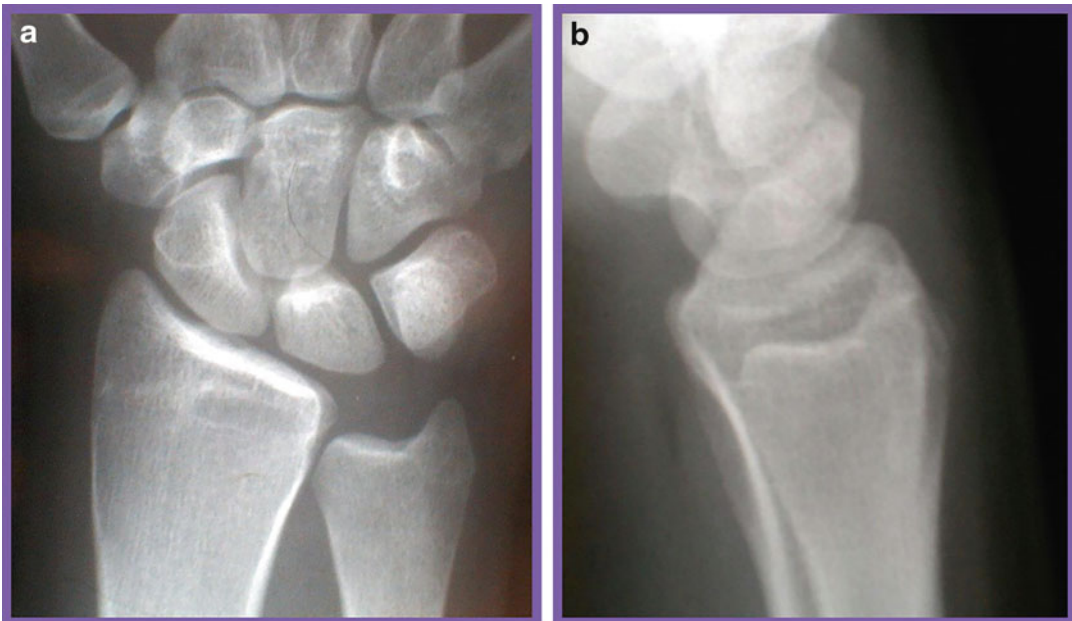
Plain X-rays before treatment. (a) Posteroanterior view reveals a normal appearance of the lunate and a negative ulnar variance. (b) Lateral view demonstrates a normal-appearing lunate
